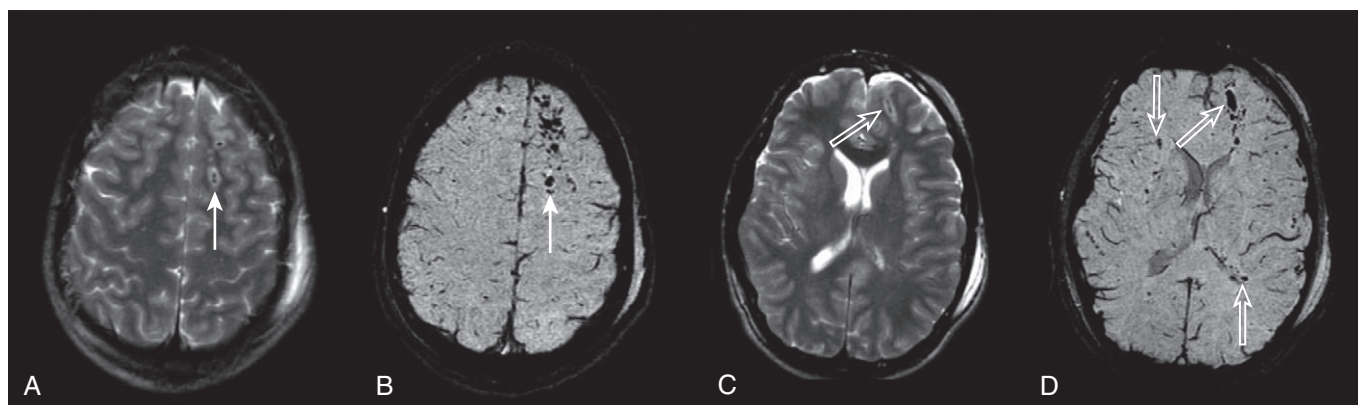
Detection of diffuse axonal injury is enhanced by susceptibility-weighted magnetic resonance imaging (SWI). A, Subtle hemorrhage in white matter is seen with conventional axial T2-weighted imaging. B, The diffuse white matter hemorrhages are much more readily detectable on SWI. (From Tong KA, Ashwal S, Obenaus A et al: *Susceptibility-weighted MR imaging: a review of clinical applications in children*, AJNR Am J Neuroradiol 29:9-17, 2008.)
